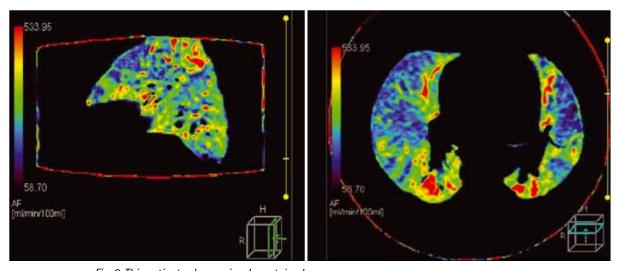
This patient, who previously sustained a massive pulmonary embolism, remained symptomatic 3 months after the inital event. Despite an apparently normal conventional CT pulmonary angiogram, there are areas of strikingly reduced perfusion in the infero-posterior regions of the lungs. Some of these areas demonstrate segmental distribution and are likely to represent chronic post-thrombotic occlusion.
